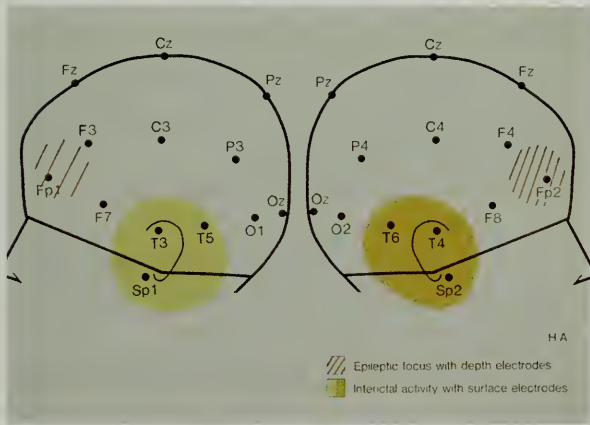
EEG mapping in this patient (A) showed bitemporal abnormalities with surface recording, while depth electrode recordings indicated bifrontal activity. The FDG-PET scan (B) agreed with the depth electrode findings, showing severely decreased cerebral glucose metabolism in both frontal lobes (arrows).
